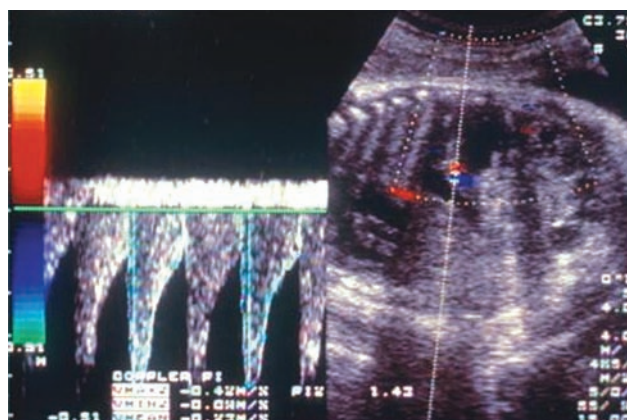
Neuroblastoma. Solid tumor and heterogenous. Color Doppler shows artery blood flow.
